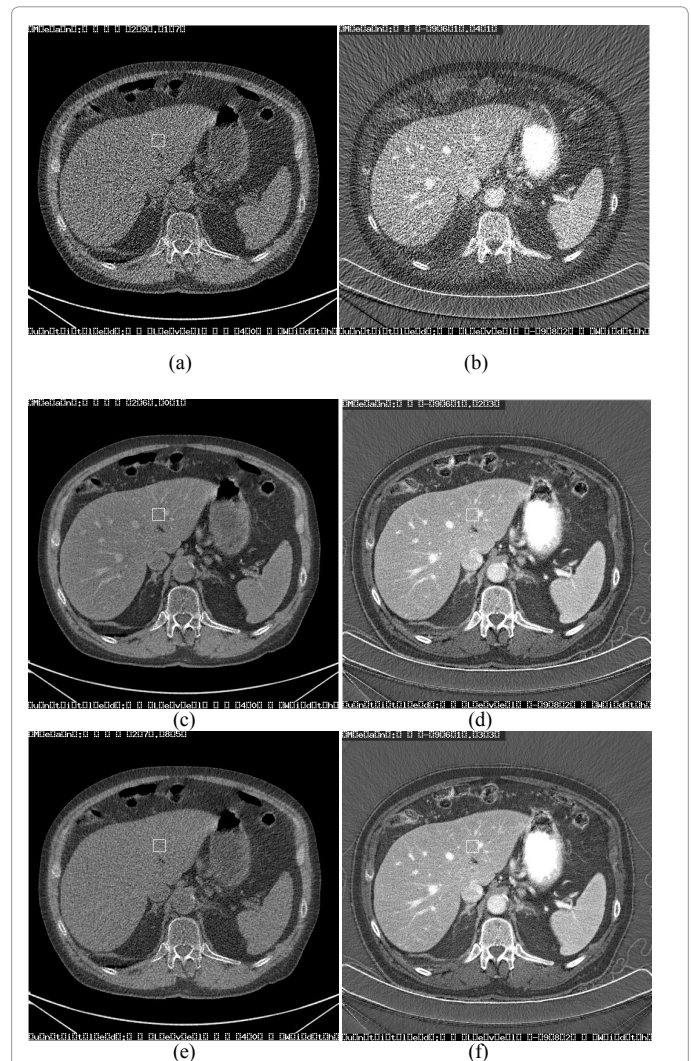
Example of noise suppression of a FKS dual-energy CT imaging using the correlated anisotropic diffusion algorithm. (a) Original water density image. (b) Original iodine density image. (c) Noise reduced water density image using a single-pass algorithm, where the cross-contaminated structures are clearly visible throughout the liver area. (d) Noise reduced iodine density image using a single-pass algorithm. The iodinated hepatic vessels are the root cause of the cross-contaminations seen in the complimentary water image in (c). (e) Noise reduced water density image using the two-pass algorithm is free of contamination. (f) Noise reduced iodine density image using the correlated anisotropic diffusion algorithm. Image adapted from Li et. al, BioMed Research International (2013-in press).
